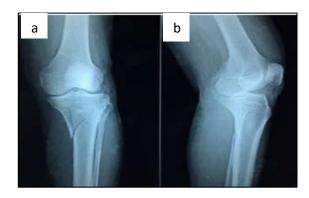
(a & b): Pre-operative X-ray of the patient.
